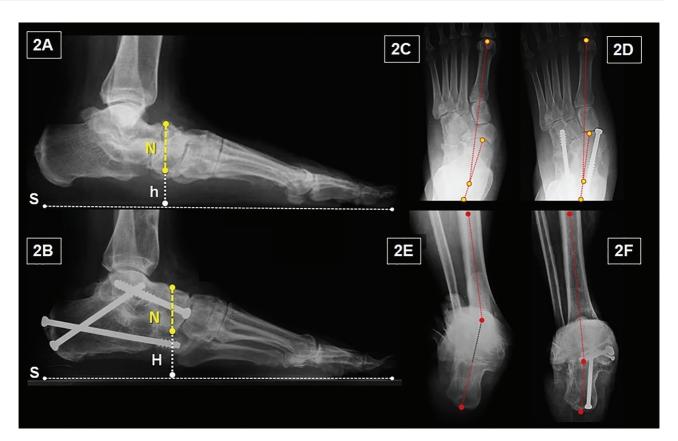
Radiographic lateral image of the foot and ankle showing collapse of the medial arch (2A), which was corrected after the surgery (2B). The arch height in both pre- (h) and postoperative (H) images is determined by the distance of the lower margin of the navicular axis (N) towards the ground (S). Anteroposterior radiographic image of the foot, showing abduction before (2C) and after surgical correction (2D). Axial-to-foot radiographic image showing valgus deformity (2E) corrected with surgery (2F).
